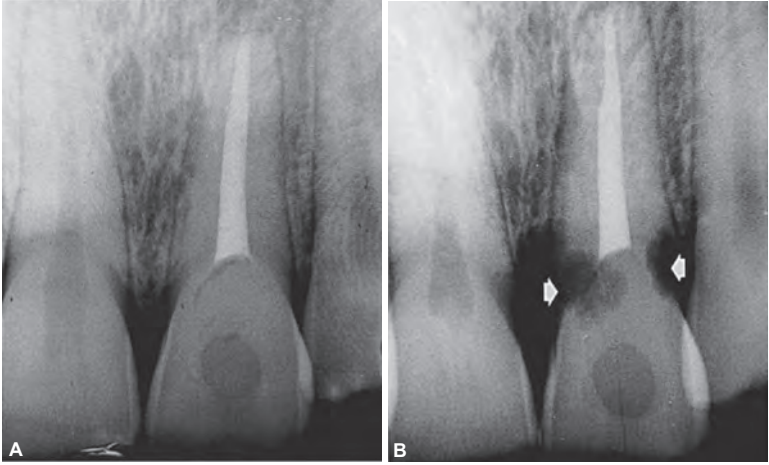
Post bleaching external resorption. A, Nine-year follow up radiograph of a central incisor devitalized by trauma and treated endodontically shortly thereafter. B, Radiograph taken 2 years following bleaching. Superoxol and heat were used first followed by “walking bleach” with Superoxol and sodium perborate. Reproduced with permission from D. Steiner and G. Harrington.
